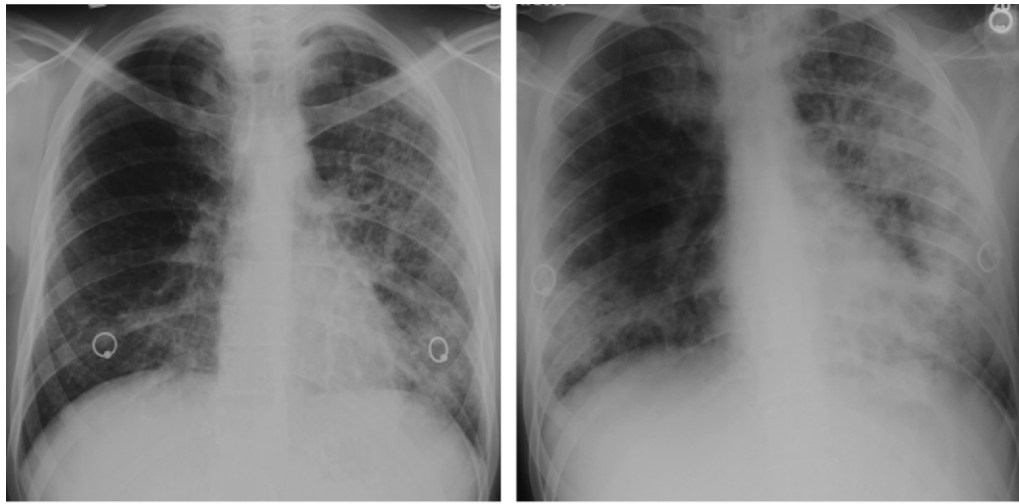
Pneumocystis pneumonia*-IRIS in an HIV-infected 30-year-old man with a CD4 count of 100 cells/ μ L. (a) Chest radiograph shows *Pneumocystis pneumonia*, mostly on the left side. Clinical improvement was seen within 2 weeks of the initiation of treatment for this condition, and ART was initiated; within 5 days, however, dyspnea, cough, and hypoxia increased. (b) Follow-up chest radiograph shows worsening of lung consolidation, a finding that was attributed to *Pneumocystis pneumonia*-IRIS.
